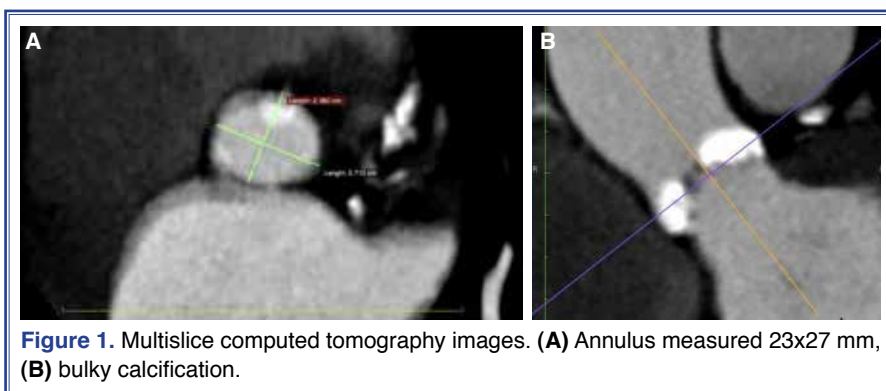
Multislice computed tomography images. (A) Annulus measured 23x27 mm, (B) bulky calcification.
